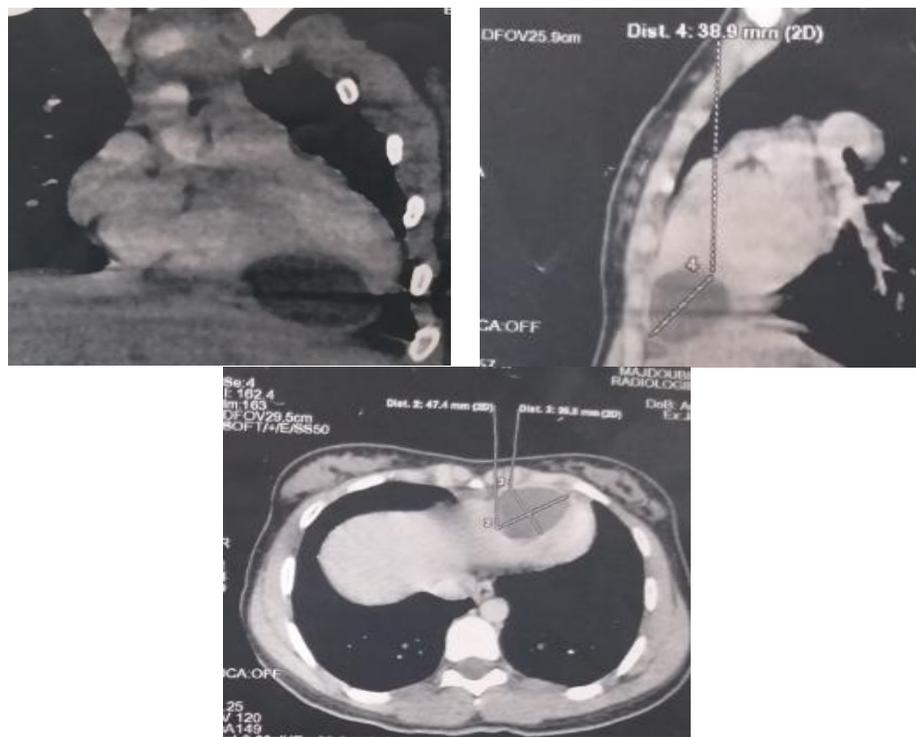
Cardiac CT scan showing a right intraventricular hydatid cyst
